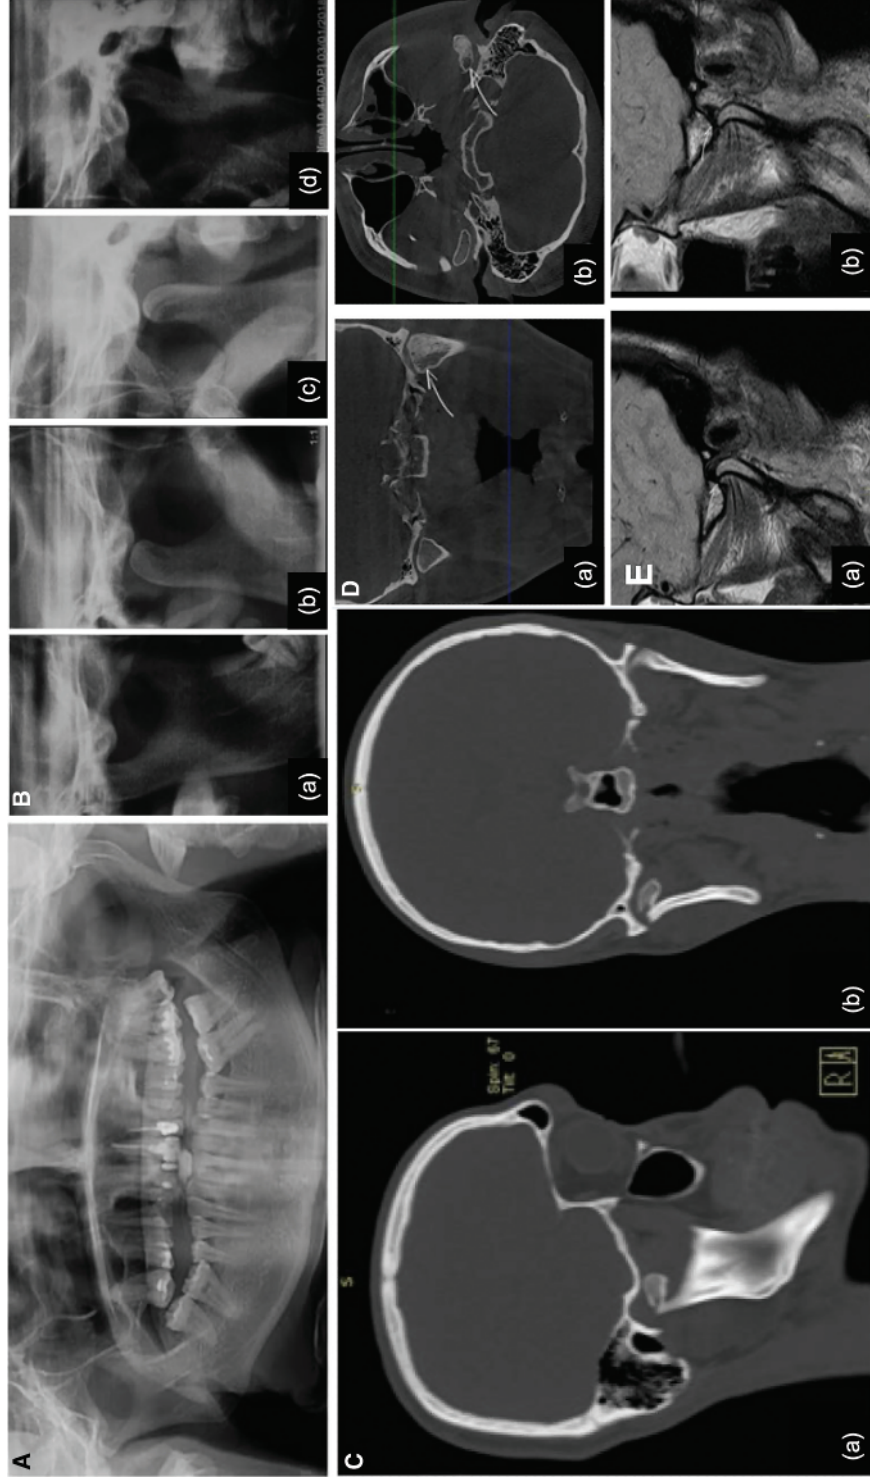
Various imaging techniques for the temporomandibular joint. A, Panoramic radiography. B, Plain radiography (transcranial projection) [(a) and (d) Closed-mouth, (b) and (c) Open-mouth]. C, Computed tomography [(a) Sagittal plane, (b) Coronal plane]. D, Cone-beam computed tomography [(a) Coronal plane, (b) Axial plane]. E, Magnetic resonance imaging [(a) Closed-mouth, (b) Open-mouth]. Reproduced from [12] / with permission of Kathmandu University Medical Journal (KUMJ) Kathmandu University.
